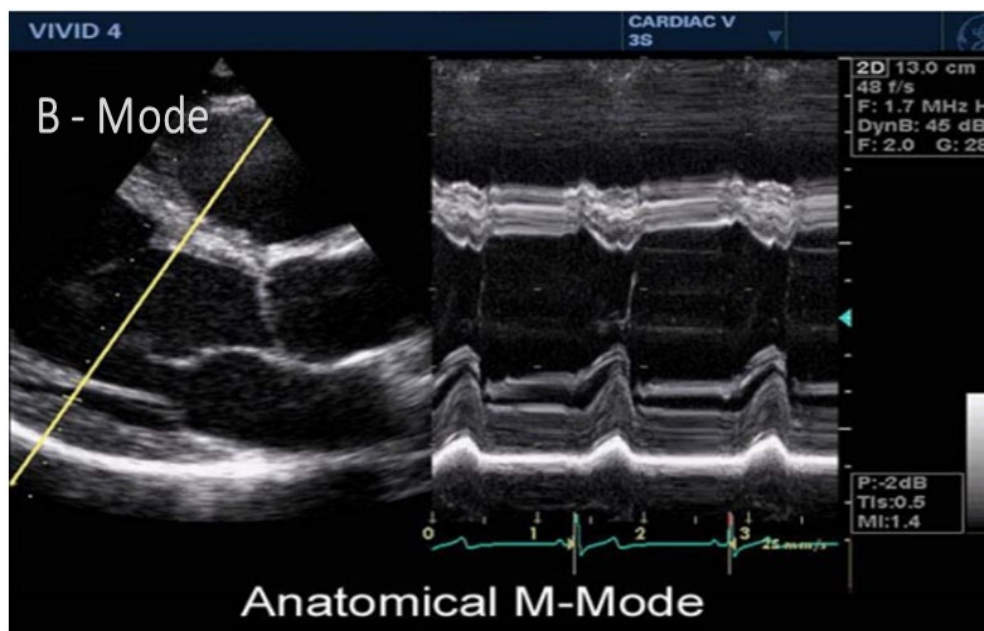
Ultrasound B mode image of left ventricle. The operator chooses a region on B mode to display the structure underlying the cursor line. The reflected echoes under the line displayed in combination with M mode.
